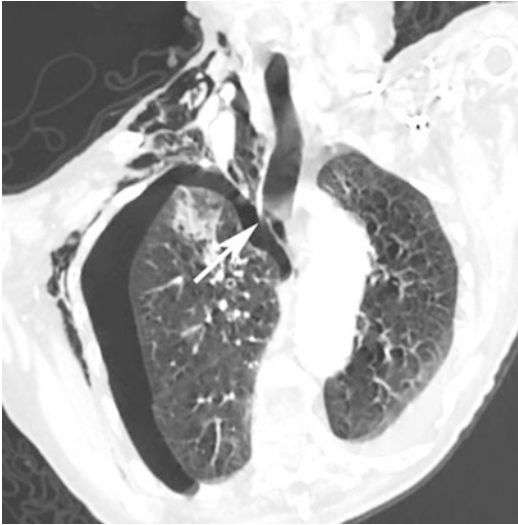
Coronal CT reconstruction demonstrates a focal discontinuity of the right wall of the trachea (*white arrow*) associated with ipsilateral pneumothorax and subcutaneous emphysema
